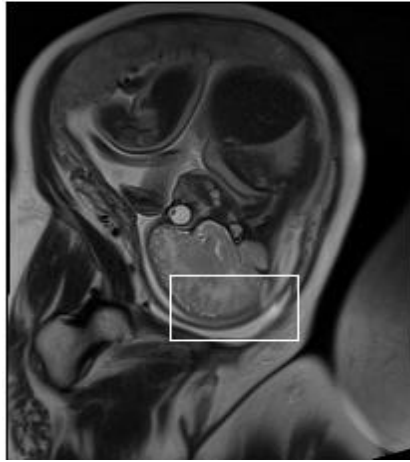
Presence of melted CSF and cortex in fetal MRI
